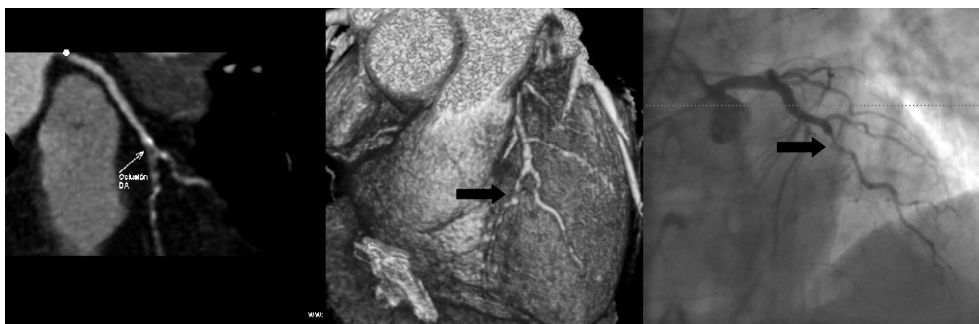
Concordance between multidetector CT and cardiac catheterization. Curved multislice reconstruction (left), three-dimensional reconstruction (center) and catheterization (right) in a patient with occlusion of the left anterior descending artery (arrows).
